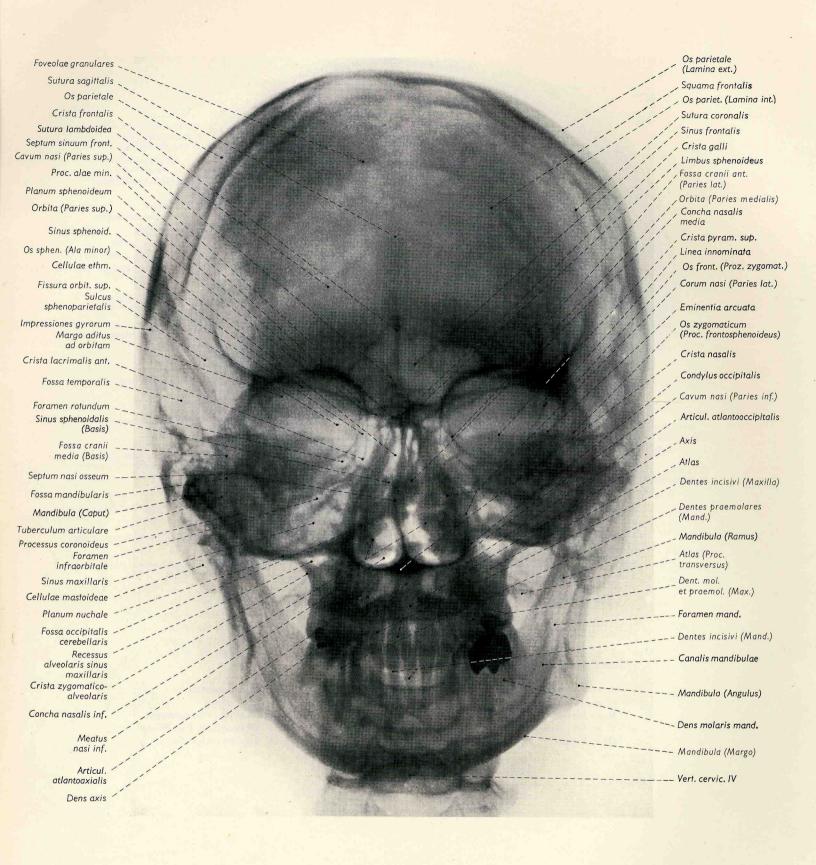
Posteroanterior roentgenogram of skull (from Clementschitsch).
